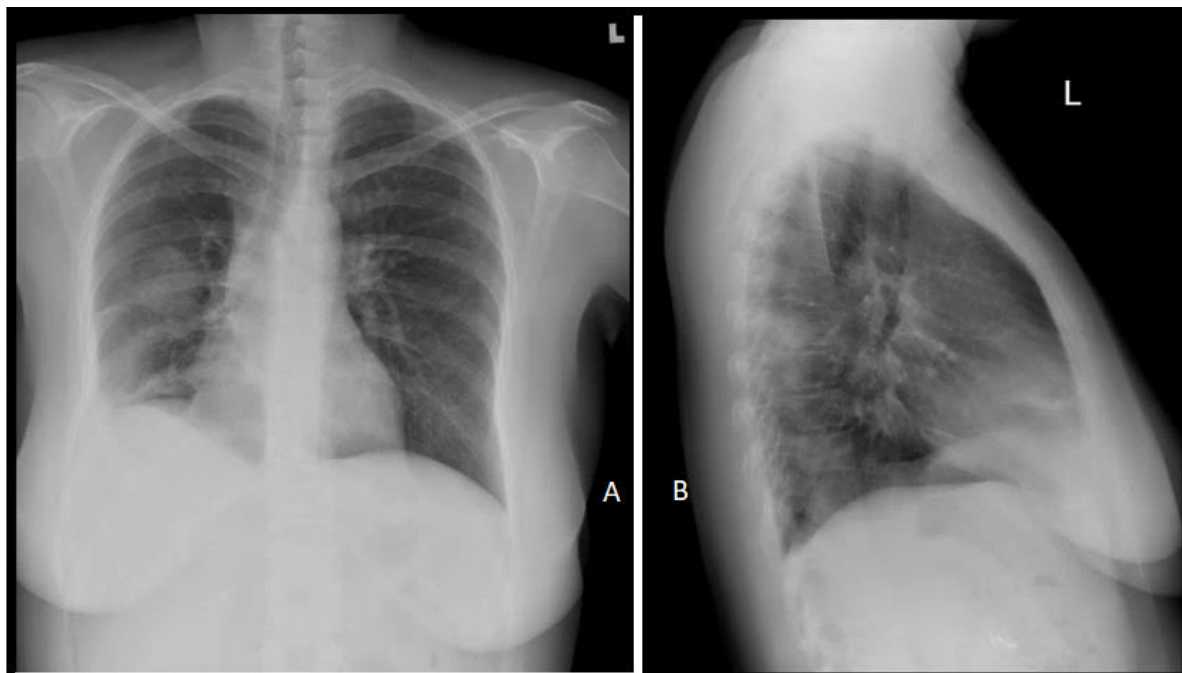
Chest x-ray, (A) Showed a rounded low density opacity projected over the right mid lung zone, (B) Identified posteriorly on the lateral view representing a right lower lobe apical segment consolidation/atelectasis.
